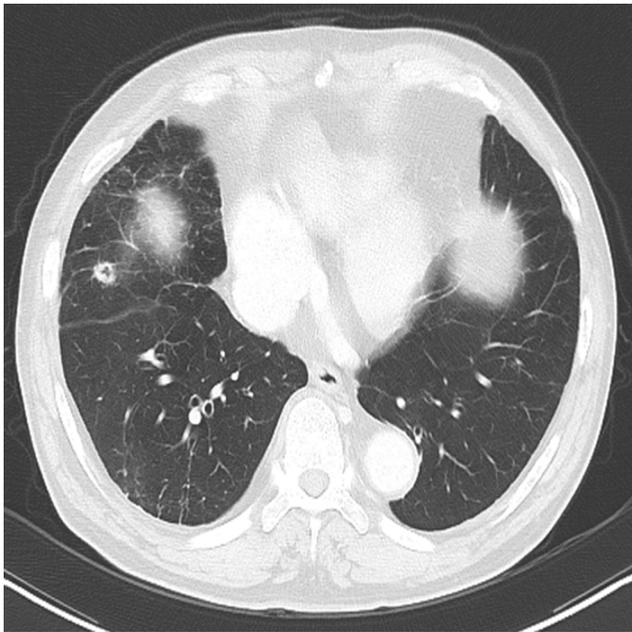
A CT scan after 2 years of erlotinib treatment showed a new nodule in the right middle lobe.
